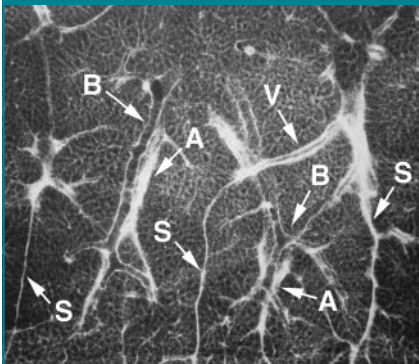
Radiograph of 1-mm lung slice taken from peripheral lower lobe. Two well-defined secondary pulmonary lobules are visible. Lobules are margined by thin interlobular septa (S) containing pulmonary vein (V) branches. Bronchioles (B) and pulmonary arteries (A) are centrilobular. (Reprinted, with permission, from reference 10.)
